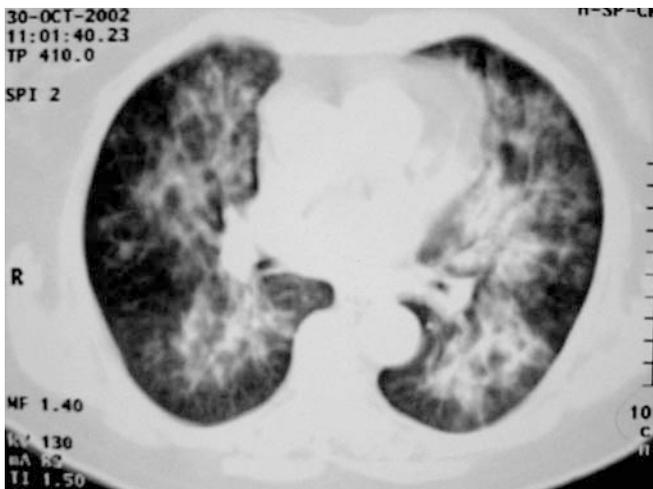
On CT scan, which was performed 6 months later, bilateral perihilar alveolar infiltrates with air bronchograms are seen
